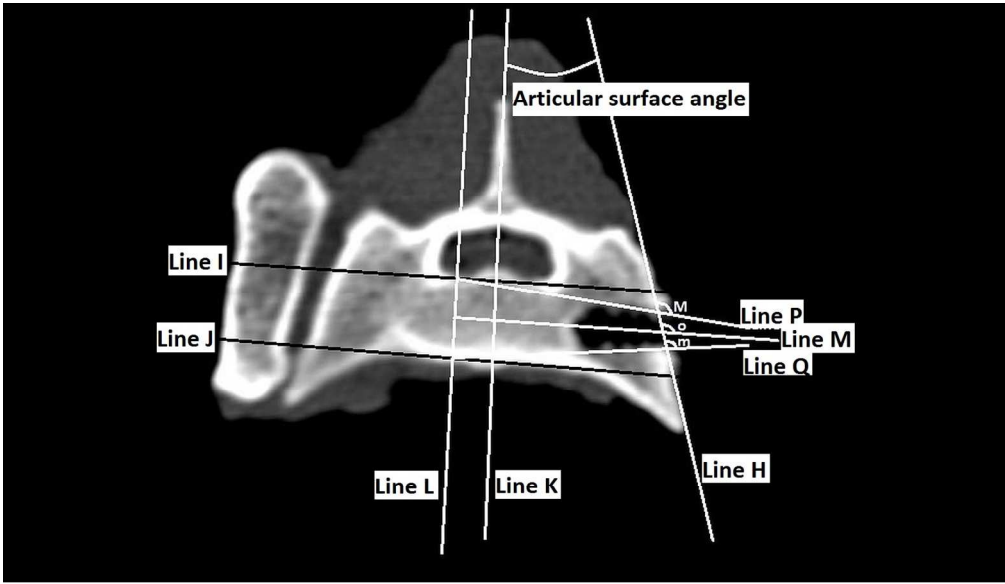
close-up. Radiographic evaluation of the craniocaudal safe corridor (close-up).
